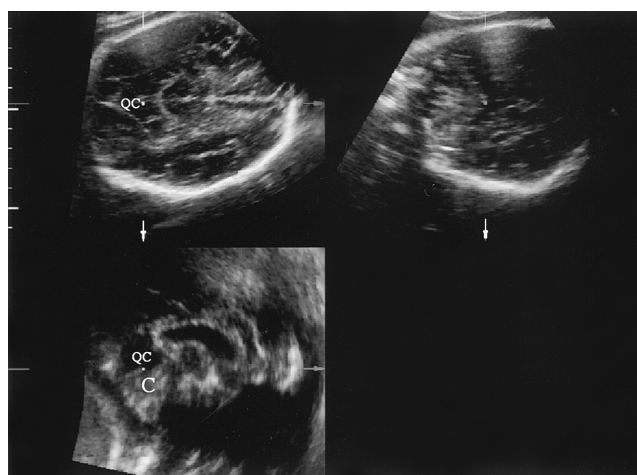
The spatial relationship of the quadrigeminal cistern (QC) to the cerebellum (C) is shown in three-dimensional ultrasonographic images of the fetal head at 30 weeks of gestation. Transverse section at the biparietal diameter plane, coronal section and sagittal section are shown in the left upper, right upper and lower panels, respectively.
